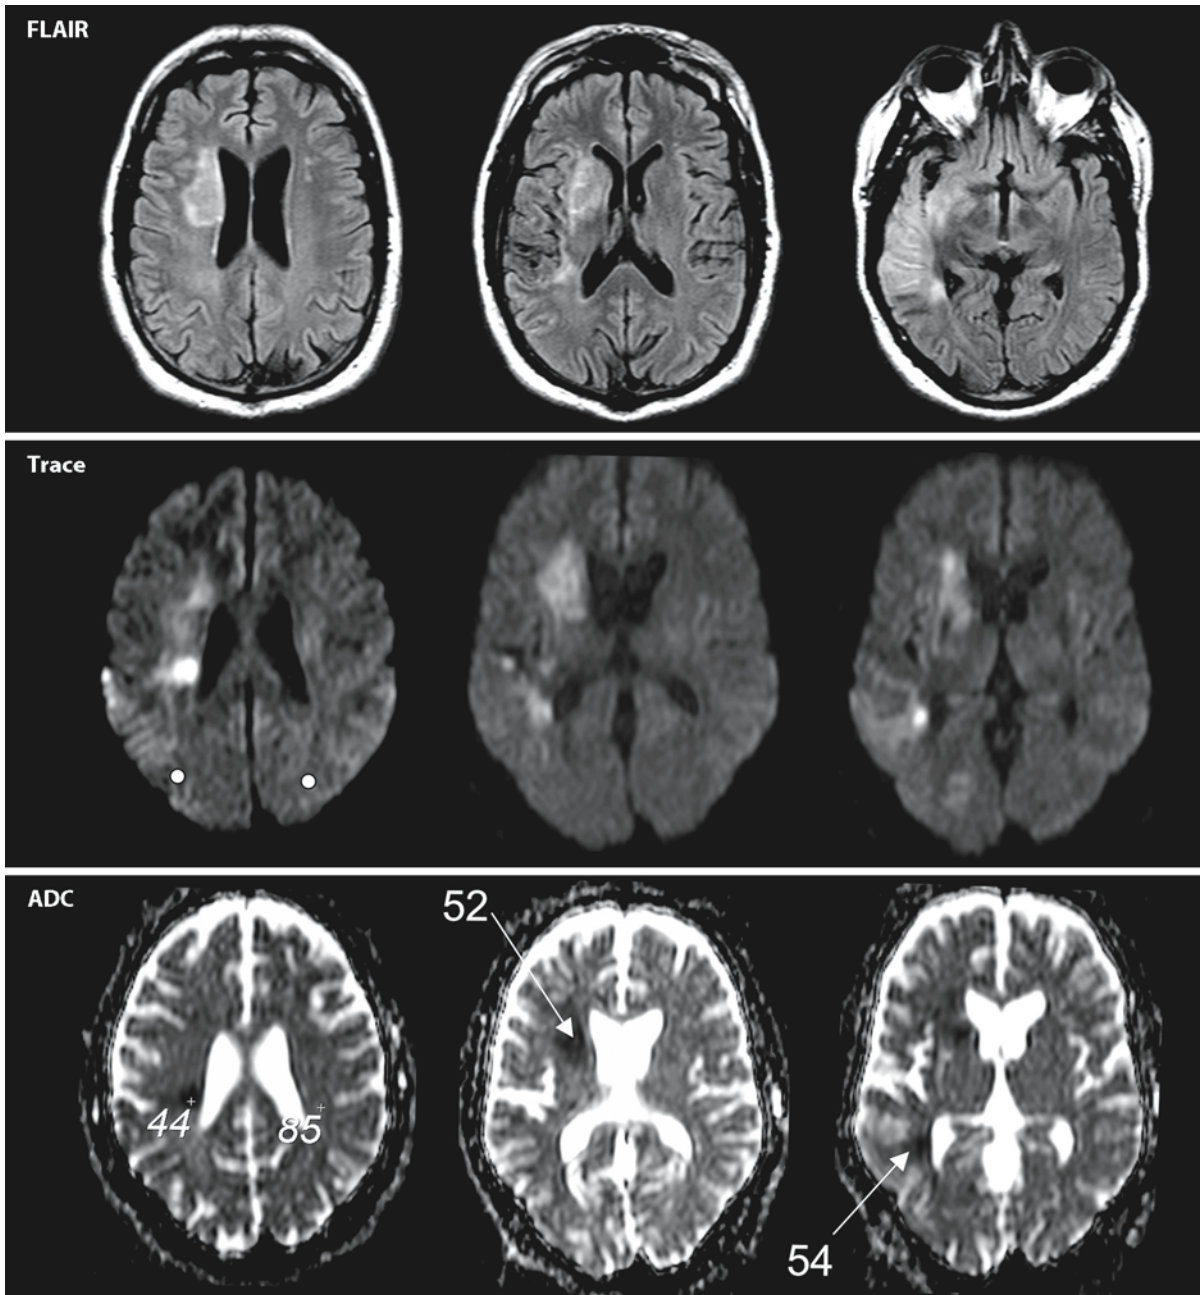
DWI and ADC maps, often in combination with perfusion imaging, play an important role in stroke units, to identify salvageable tissue. This set of images shows such a practical application in a 66-year-old stroke patient. The *upper row* of FLAIR images shows lesions in the right middle cerebral artery territory. The *second row* of DWI–Trace images shows
